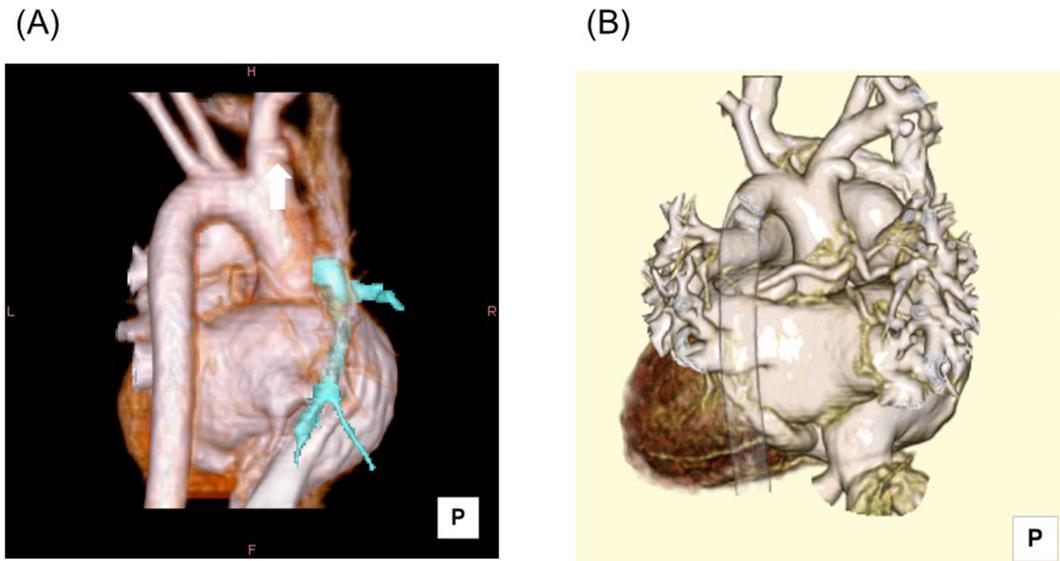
Posterior views of 3D computed tomography of Patient 2
